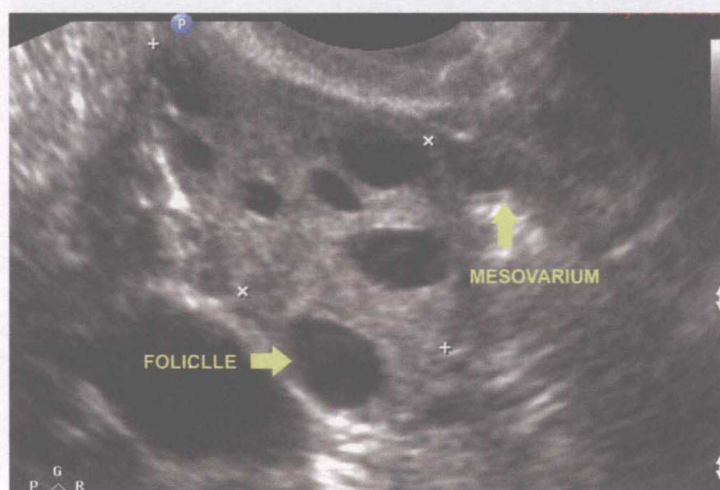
Transvaginal ultrasound of the ovary, showing the normal anatomy
